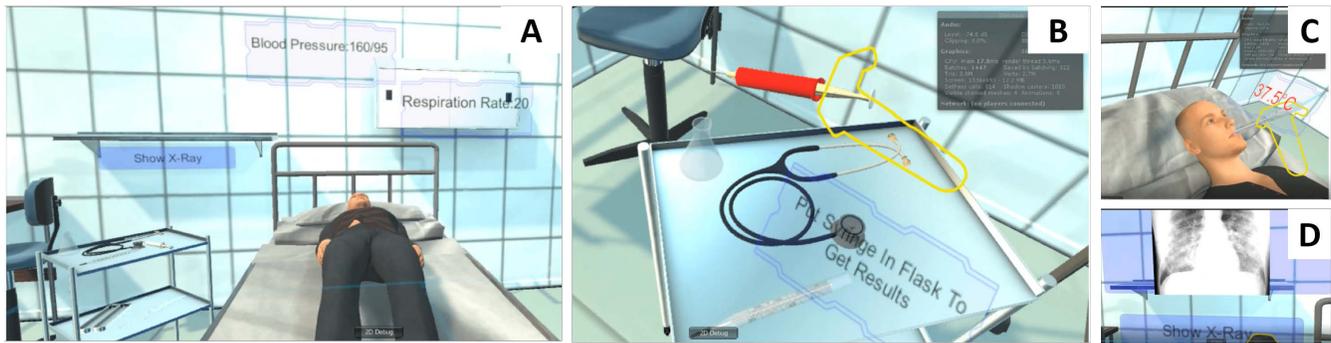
Screenshots from our system *PathoGeniusVR* to train physicians via a gamified platform in virtual reality. A) shows an overview of the environment and the available actions. B) shows a the metaphorical objects to instantiate the interaction such as a syringe. C) shows the temperature of the patient and D) shows his X-ray.
